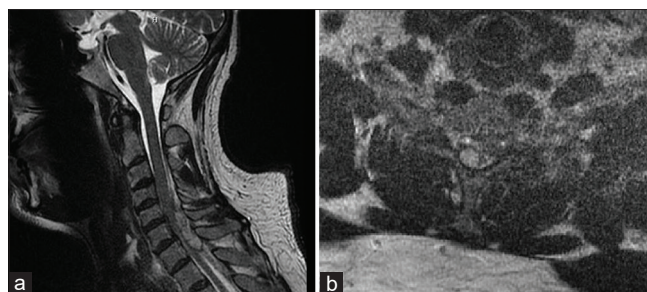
T2-weighted MRI of the cervical spine showing hyperintense epidural fluid collection with low T2 signal rim identified posterior to the cord on (a) sagittal view and (b) eccentric toward the right on axial view, at the C4-C7 levels measuring up to 1 cm thick. The cord appears compressed most pronounced at the C6 and C7 levels with mild increased cord signal.
